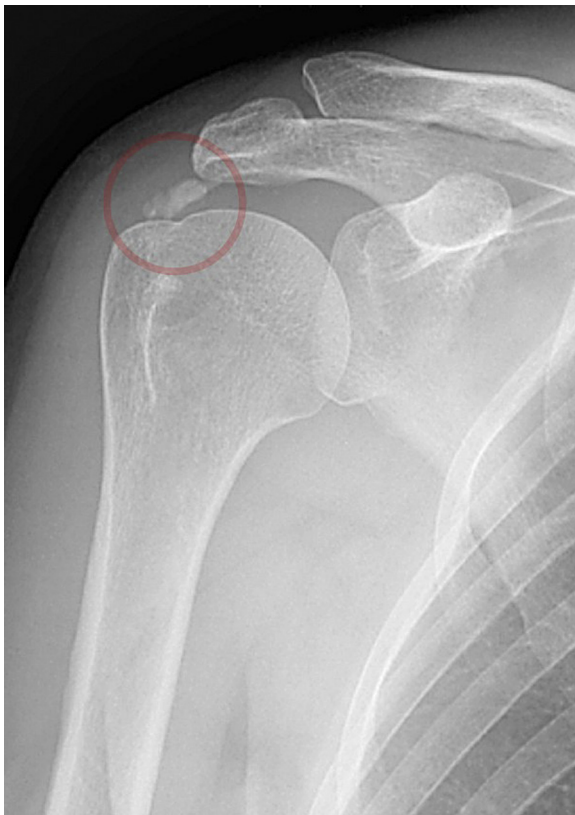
Anteroposterior radiograph, of patient's right shoulder, with calcific deposit (circle) marked within the supraspinatus tendon near its insertion on the greater tuberosity.
